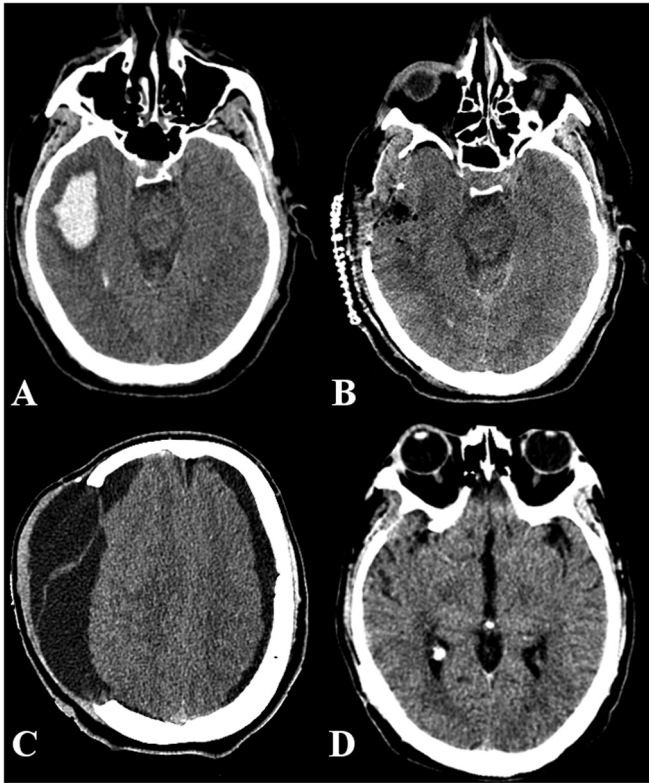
CT of first case, 43-year-old male after ground level fall. (A) Early imaging shows temporal intraparenchymal hemorrhage (5 × 2 cm). (B) Post-craniectomy flap remained sunken. (C) After neurologic decline and flap bulge were noted, repeat imaging revealed hygroma with midline shift. (D) Cranioplasty was performed 22 days after craniectomy with complete neurologic recovery.
